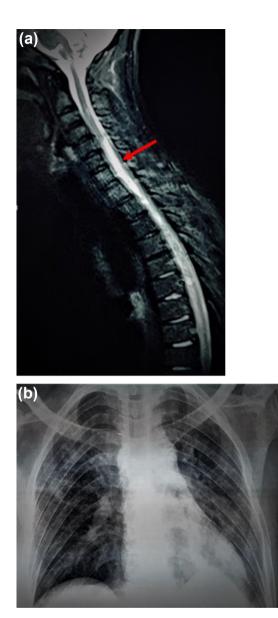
(a) Spinal cord MRI (sagittal T2 sequence) showed a longitudinally extensive transverse myelitis extending from C5 to T10 (red arrow). (b) Posteroanterior chest radiograph showed bilateral micronodular infiltrate without peripheral consolidation or pleural effusion.
